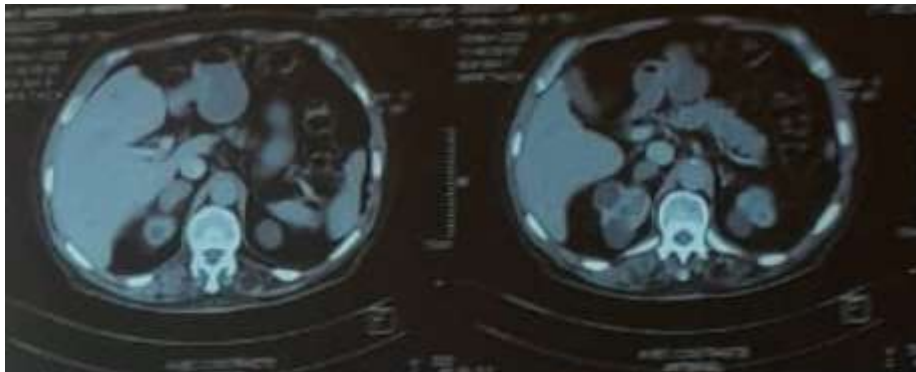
Adrenal CT scan showing:
